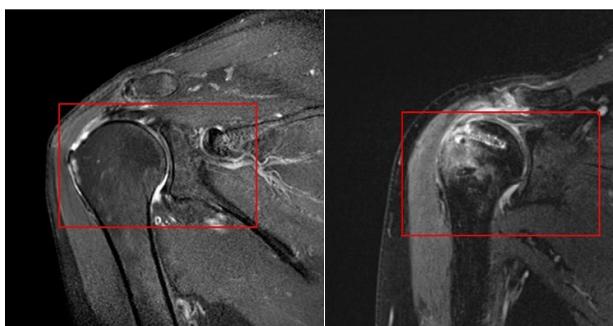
Representative MRI images of a patients with rotator cuff tear (A) before and (B) after the arthroscopic humeral insertion displacement treatment. The injury site was marked with red rectangle.
